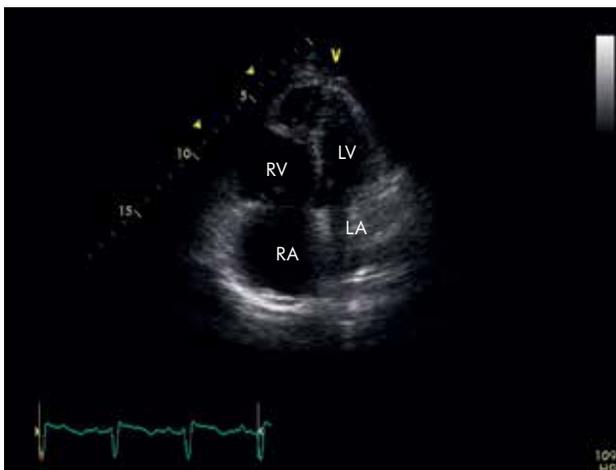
Echocardiography. Four-chamber view. Severe tricuspid regurgitation to enlarged right atrium (RA)
